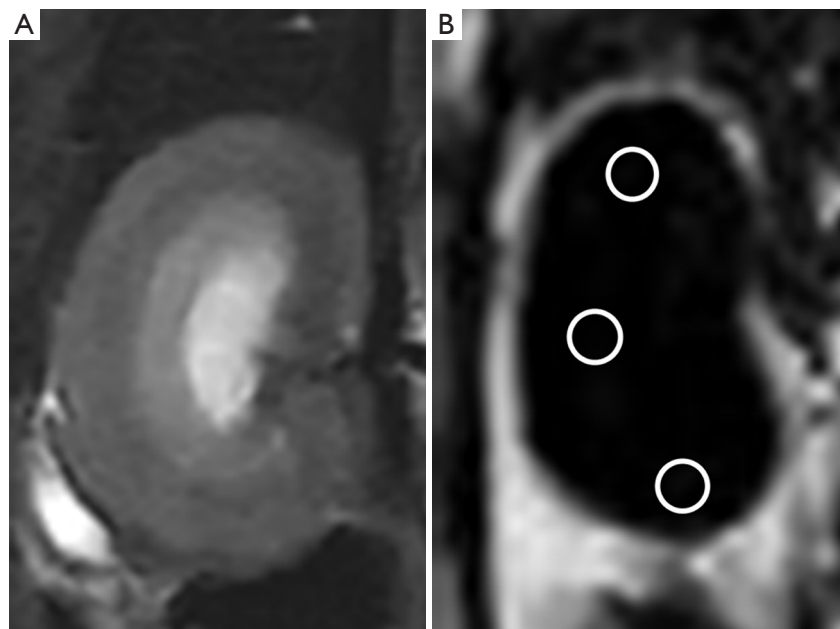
Coronal T2-weighted image (A) and fat fraction image (B) of the right kidney. Regions of interest (white circles) of the renal parenchyma were drawn in the fat fraction image (B).
